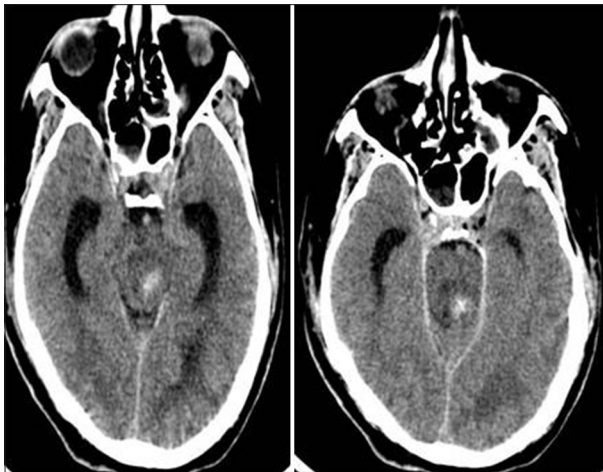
Computed tomography scan brain: Left pontine hemorrhage and edema causing compression of aqueduct
